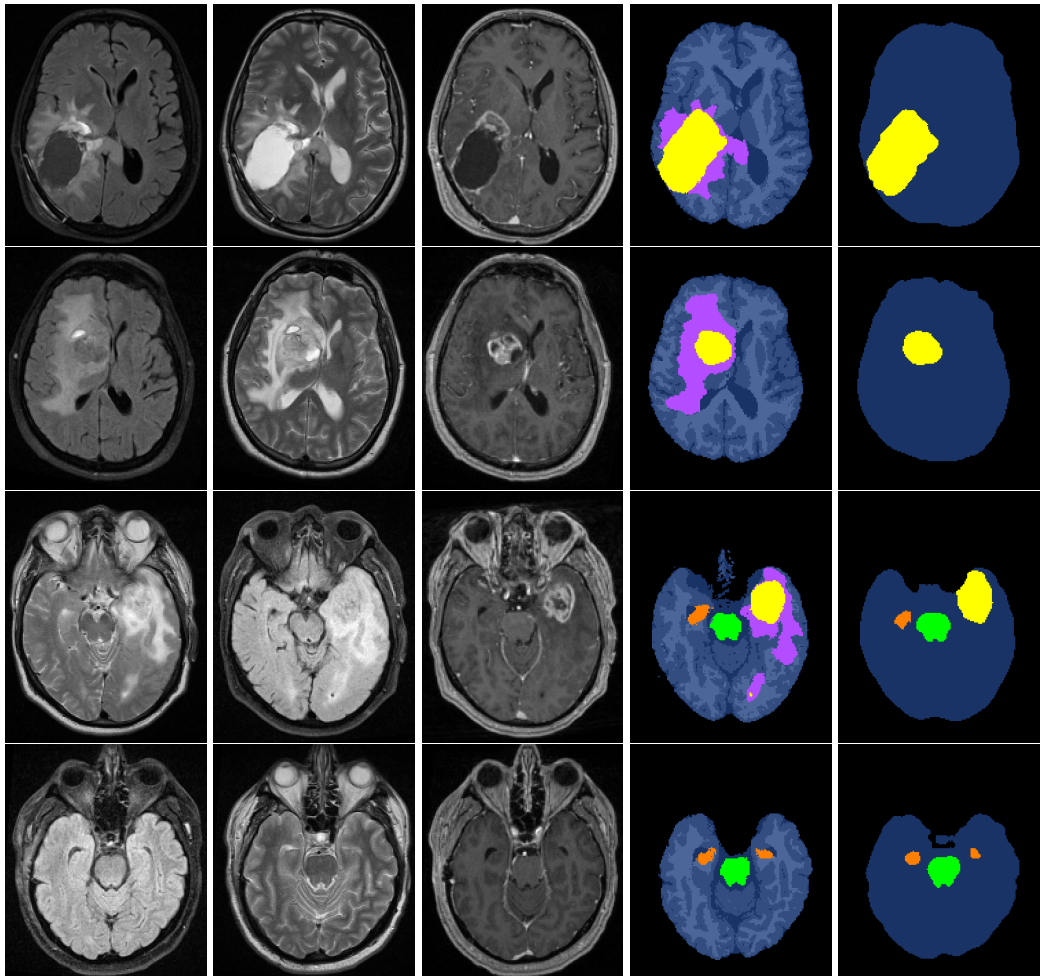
Slices of four exemplary subjects. From left to right: MR-contrasts: FLAIR, T2 and T1c; segmentation by method; and manual segmentation. GTV is in yellow, brainstem is in green, hippocampus is in orange, edema is in lilac, non-brain tissue is in black and healthy superstructures are in shades of blue.
